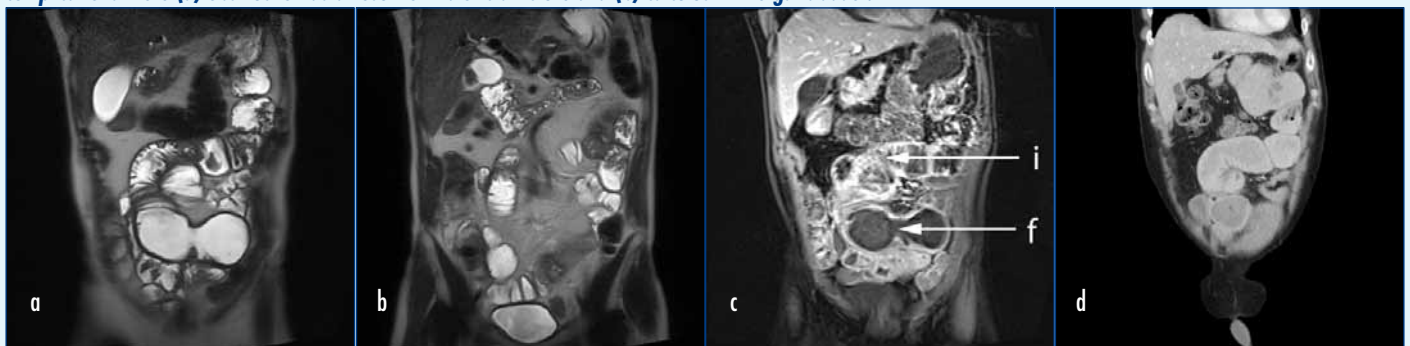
Advanced Crohn's disease. a, b. Magnetic resonance imaging shows multi-segmental involvement of small bowel with several skip lesions and strictures. c. Contrast-enhanced magnetic resonance imaging helped to differentiate between active inflammatory process (i) and fibrotic stricture (f). Subsequent complications were (d) obstruction as a result of fibrotic stricture and (b) calculus in the gallbladder.
